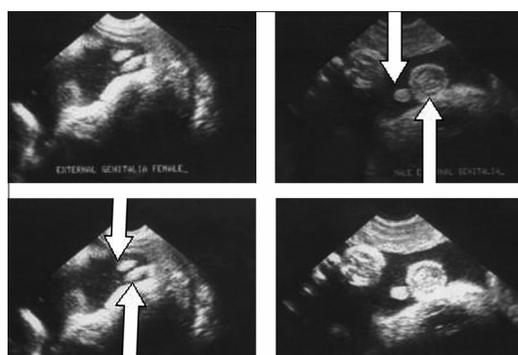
Sonographic appearance of external genitalia
